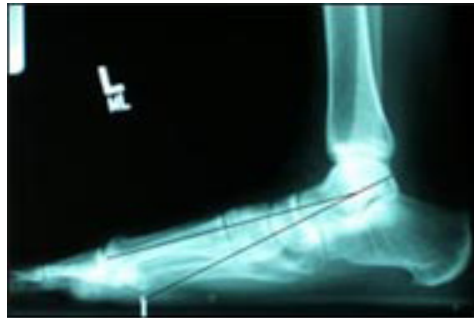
X-Rays of Acquired Flat Foot Deformity
